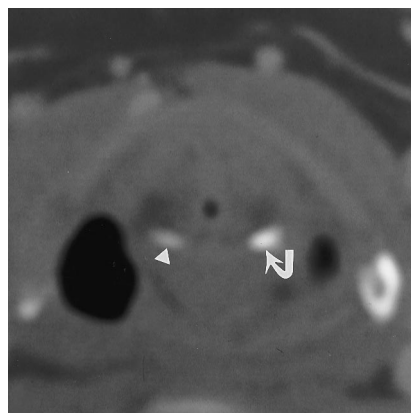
CT scan through the superior process of the arytenoid cartilage obtained in a bone window shows marked sclerosis of the superior process on the left side (*arrow*) as compared with the right (*arrowhead*). This scan was obtained as a follow-up examination in an asymptomatic 39-year-old woman after superficial parotidectomy on the right for benign pleomorphic adenoma 1 year before this study.
